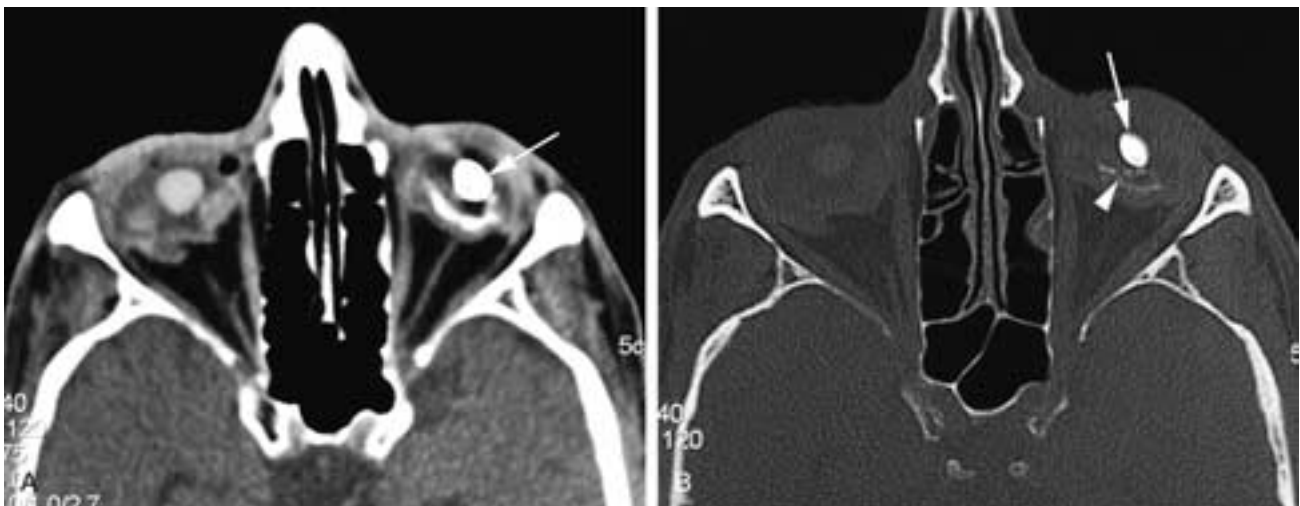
Acute perforation of the globe on the right side. Phthisis bulbi and calcified lens on the left side. Axial CT scans at narrow (A) and wide (B) window settings. There is inward buckling of the sclera of the right globe after acute trauma. There is calcification along the wall of the globe on the left, with a calcified lens (*arrow*) from a previous insult.
